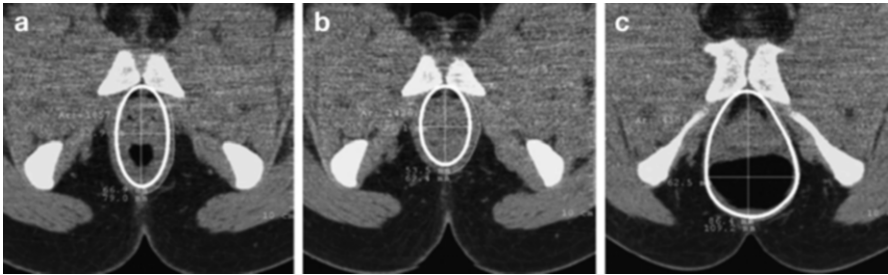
Seated CT defecography, axial images of puborectalis at rest (a), squeeze (b), and defecation (c). Note that the pelvic floor hiatus becomes smaller during squeeze and larger during defecation (Adapted from Li D, Guo M. Morphology of the levator ani muscle. *Dis Colon Rectum*. Nov 2007;50(11):1831–1839, with permission)
